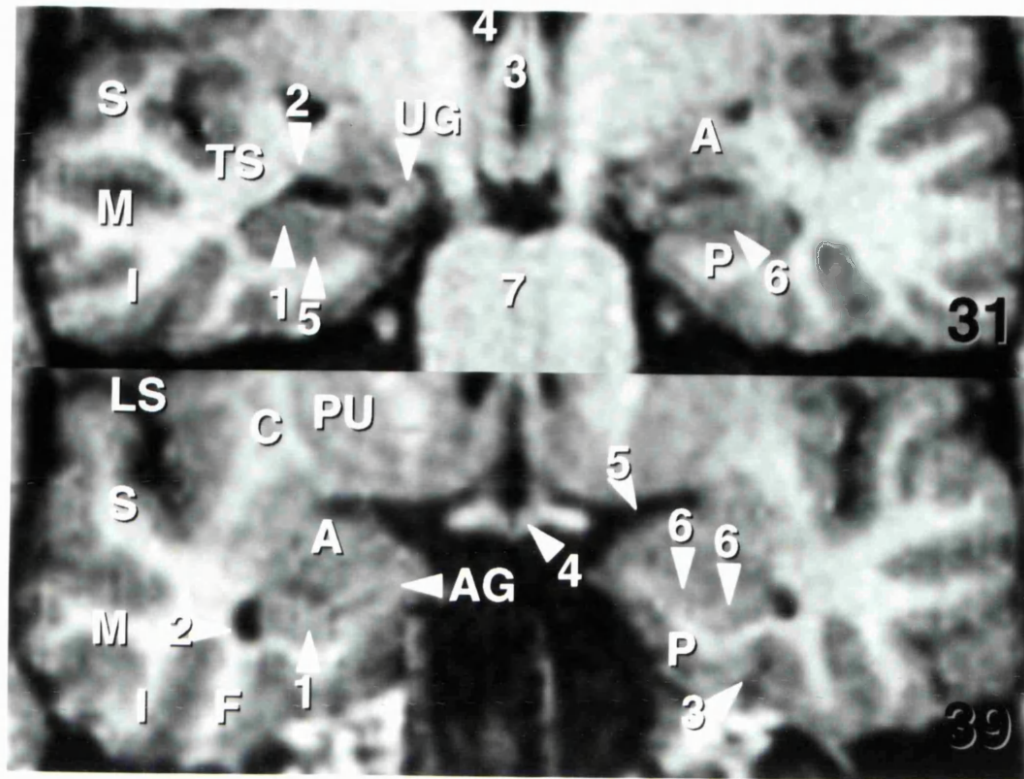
The hippocampal head. Section 31 and 39 of the same reformatted control MPRAGE as the previous Figure. Section 31. The hippocampal head (1) with digitationes hippocampi is separated from the subiculum (5) by the uncus (6), and from the amygdala (A) by the uncus recess of the temporal horn (2). The uncinate gyrus (UG) connects the medial hippocampus with the amygdala (A). Third ventricle (3), body of lateral ventricle (4), brainstem (7), superior temporal gyrus (S), middle temporal gyrus (M), inferior temporal gyrus (I), fusiform gyrus (F), parahippocampal gyrus (P). Section 39. The hippocampal head (1) is smaller compared with section 31, and is bordered laterally by the temporal horn of the lateral ventricle (2), medially by the ambient gyrus (AG), superiorly by the uncus recess of the temporal horn and amygdala (A), and caudally by the parahippocampal gyrus (P). The hippocampus can be disarticulated from the amygdala by the uncus recess of the temporal horn or by the alveus, which is white on a T1-weighted image (6). Putamen (PU), caudate nucleus (C), lateral sulcus (LS), superior temporal gyrus (S), middle temporal gyrus (M), inferior temporal gyrus (I), fusiform gyrus (F), optic chiasm (4), endorhinal sulcus (5), collateral sulcus.
